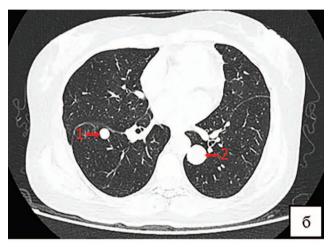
CT of the chest Note. a — multiple rounded soft-tissue neoplasms, number 1 — diameter 9.41 mm, number 2 — diameter 14.86 mm, (02.13.2020); 6 — negative dynamics, diameter of neoplasm number 1 — 12.44 mm, diameter of neoplasm number 2 — 23.85 mm, (01.24.2022)
